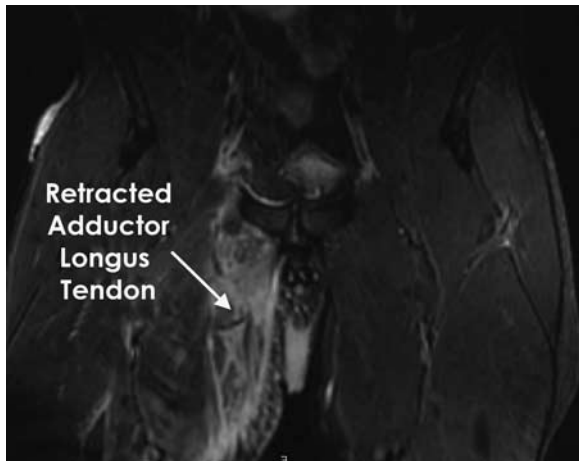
Magnetic resonance imaging (coronal cut) demonstrating a complete rupture of the adductor longus with 3 cm of distal retraction. A large hematoma can be observed in addition to increased signal surrounding the adductor brevis, pectineus, and adductor magnus.
